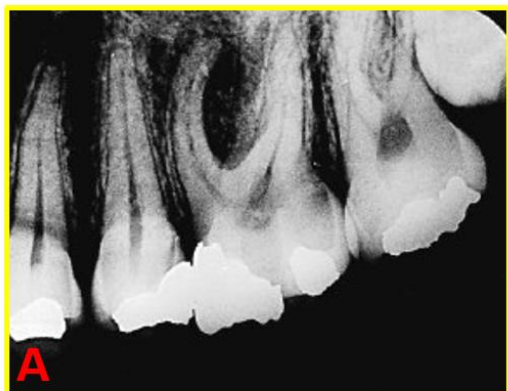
(A) Preoperative radiograph.
